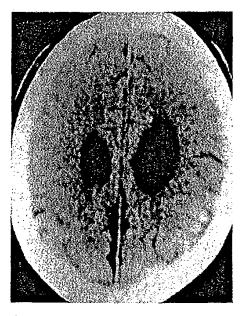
Case 1 CT brain scan showing bilateral porencephalic cysts.
